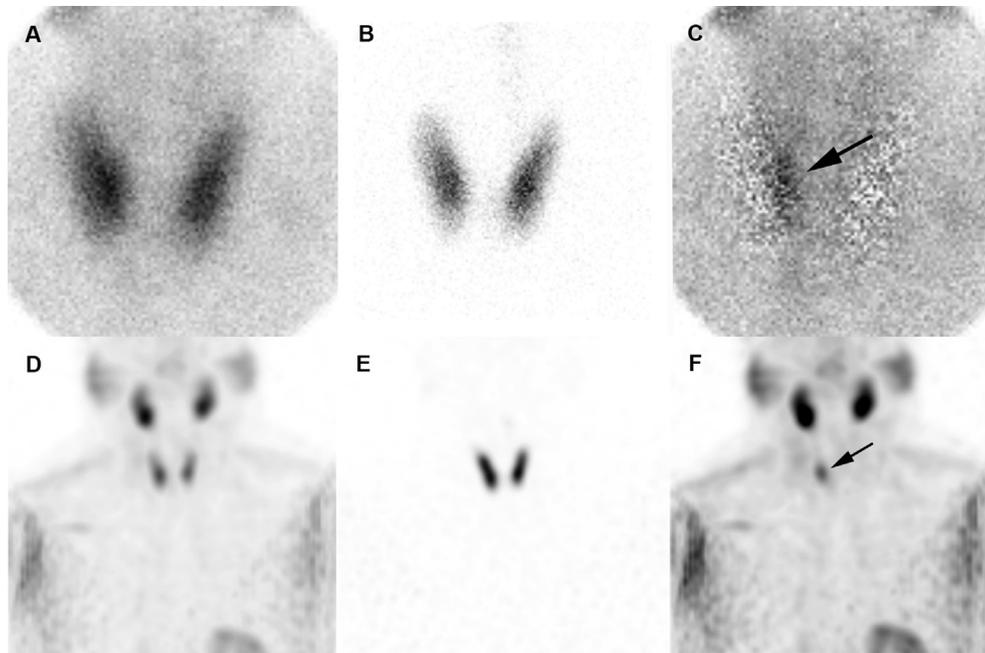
Pinhole and SPECT subtraction PS in a patient with UGD. A: ^{99m}Tc-sestamibi pinhole, B: ¹²³I pinhole, C: ¹²³I/^{99m}Tc-sestamibi subtraction pinhole, D: ^{99m}Tc-sestamibi SPECT (attenuation corrected), E: ¹²³I SPECT (attenuation corrected), F: ¹²³I/^{99m}Tc-sestamibi subtraction SPECT (attenuation corrected). The parathyroid adenoma is visible in panels C and F (arrows).
